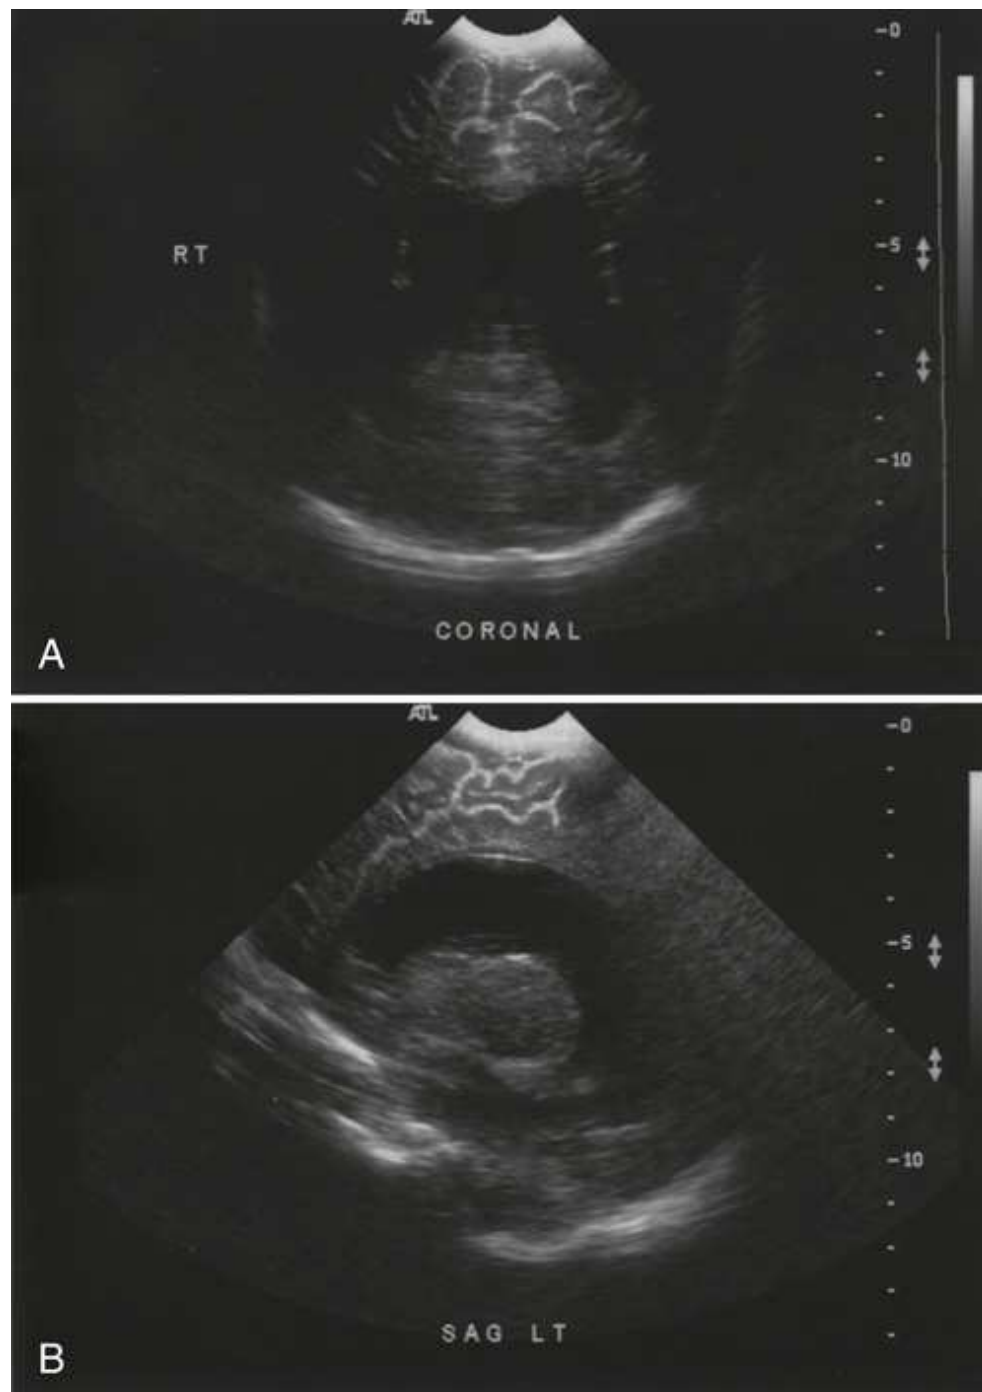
(A) Coronal sonogram in a neonate showing bilateral ventriculomegaly. (B) Sagittal sonogram of left lateral ventricle showing ventriculomegaly.
